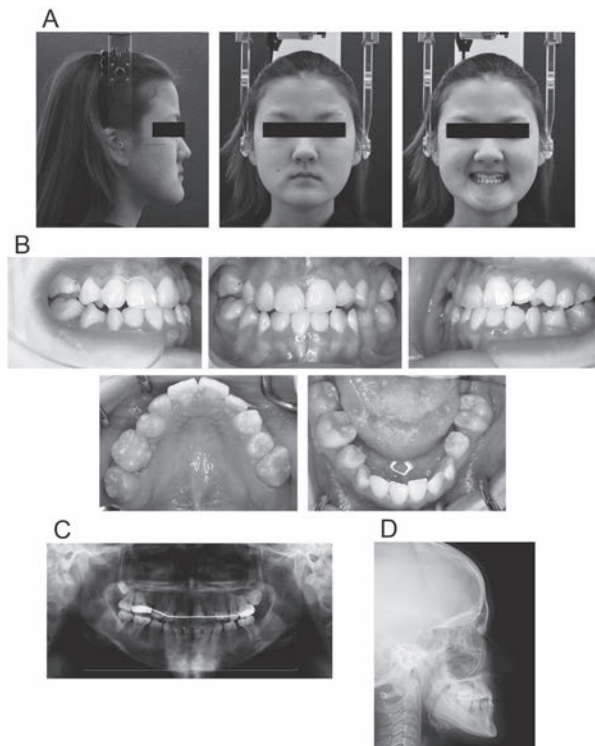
Records at the initiation of the second phase treatment (age: 17 years and 8 months). A, Facial photographs. B, Intraoral photographs. C, Panoramic radiographs. D, Lateral cephalograms.
